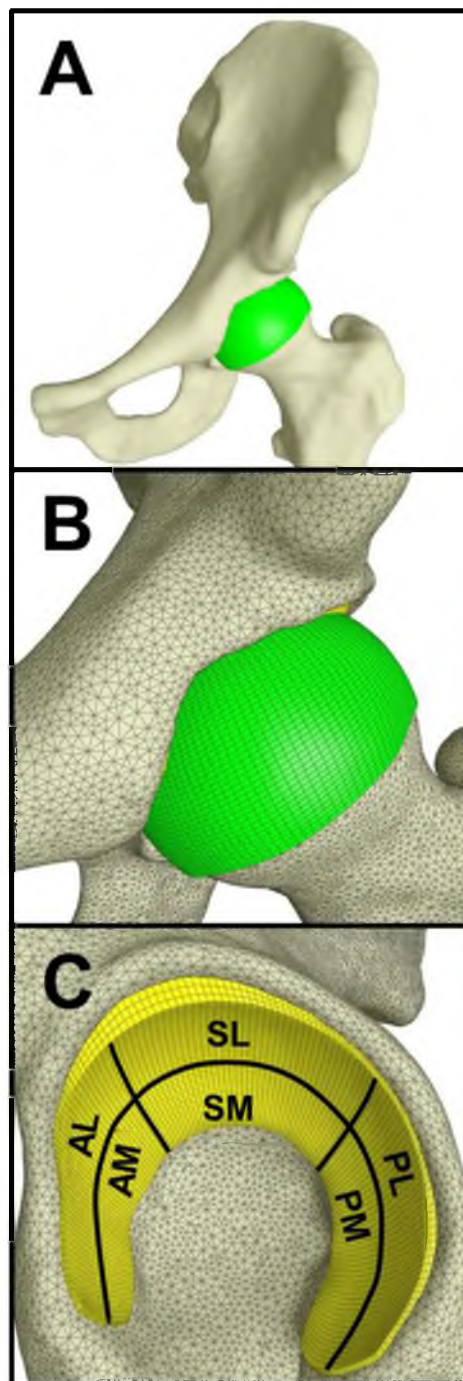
Subject-specific FE models were generated from CT data. A – anteroposterior view of a subject-specific FE model showing the bones (white) and femoral cartilage (green). B – anteroposterior view of the joint space showing discretization of the bone into triangular shell elements and the femoral cartilage into hexahedral elements. C – lateral view showing discretization of the acetabular cartilage (yellow) into hexahedral elements and the six anatomical regions on the acetabulum used for analysis of the results (AL = anterolateral, AM = anteromedial, SL = superolateral, SM = superomedial, PL = posterolateral, PM = posteromedial).
